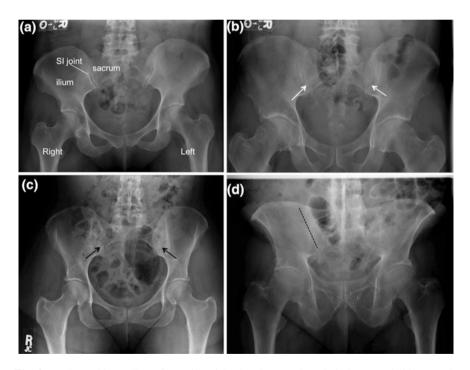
Radiographic grading of sacroiliac joint involvement in ankylosing spondylitis. a *Right* sacroiliac (SI) joint grade 0 (normal); *left* sacroiliac joint grade 1 (suspicious for changes). b *Right* sacroiliac joint grade 2, *left* sacroiliac joint grade 2 (small localized narrowing, indicated by *white arrows*). c *Right* sacroiliac joint grade 3, *left* sacroiliac joint grade 3 [partially fused with residual joint space (*black arrows*)]. d *Right* sacroiliac joint grade 4, *left* sacroiliac joint grade 4 (complete fusion). *Dotted line* indicates the location of the fused *right* sacroiliac joint
